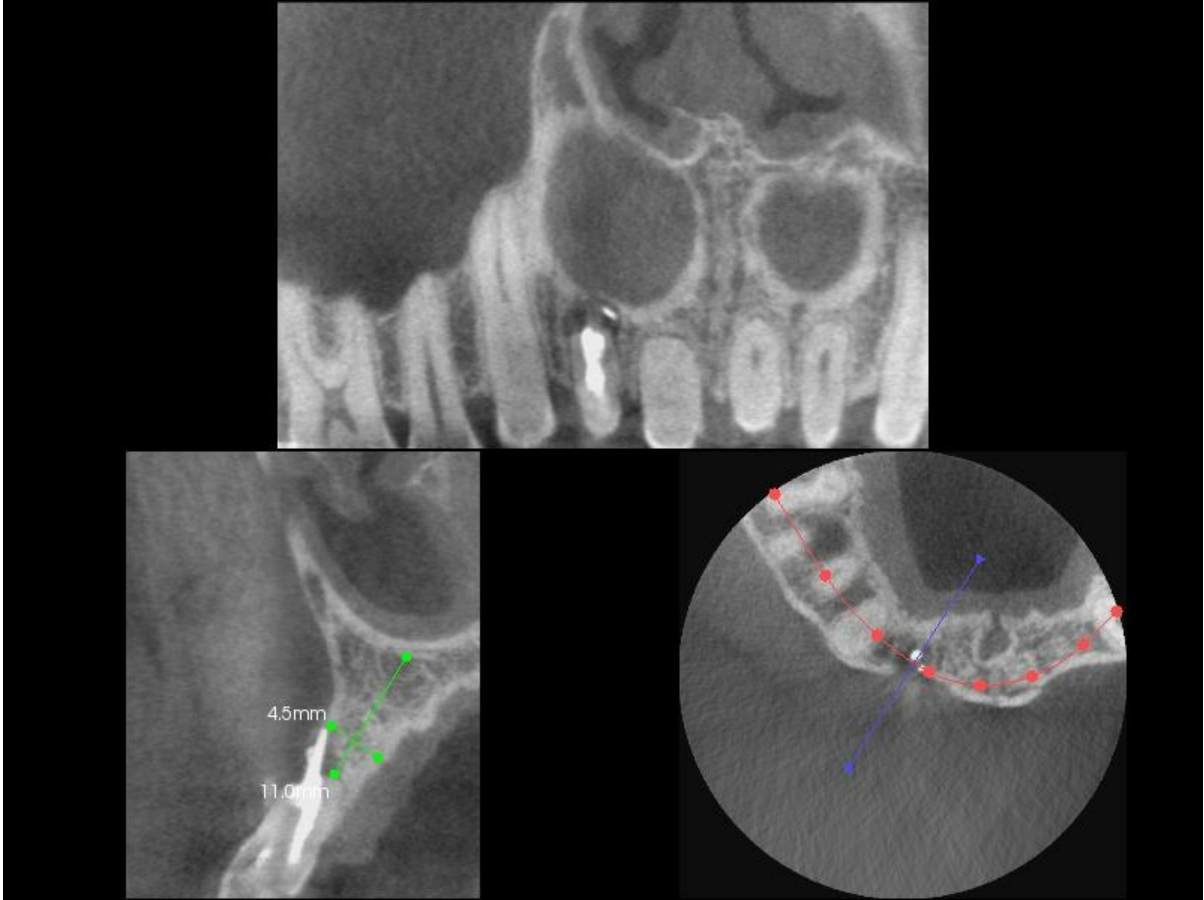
Pre-extraction CBCT of Tooth #7
